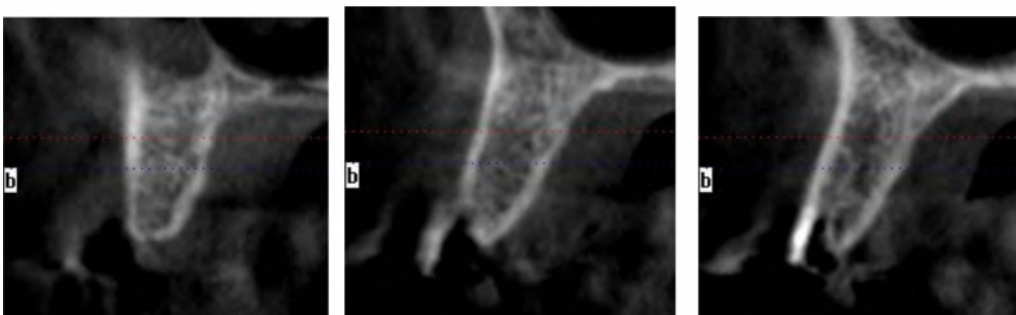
Cone beam sections of alveolar ridge
